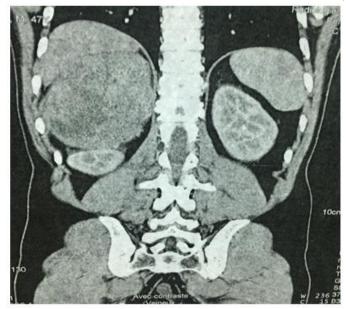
Coronal CT scan showing the right adrenal mass, with heterogeneous and solide structure.
